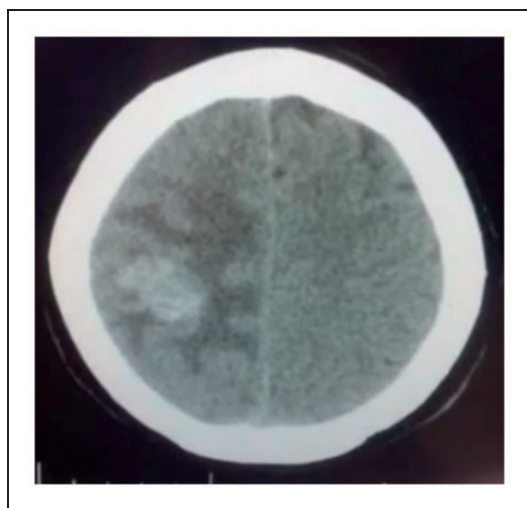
The axial brain computed tomography scan shows a hyperdense mass with surrounding hypodensity.
